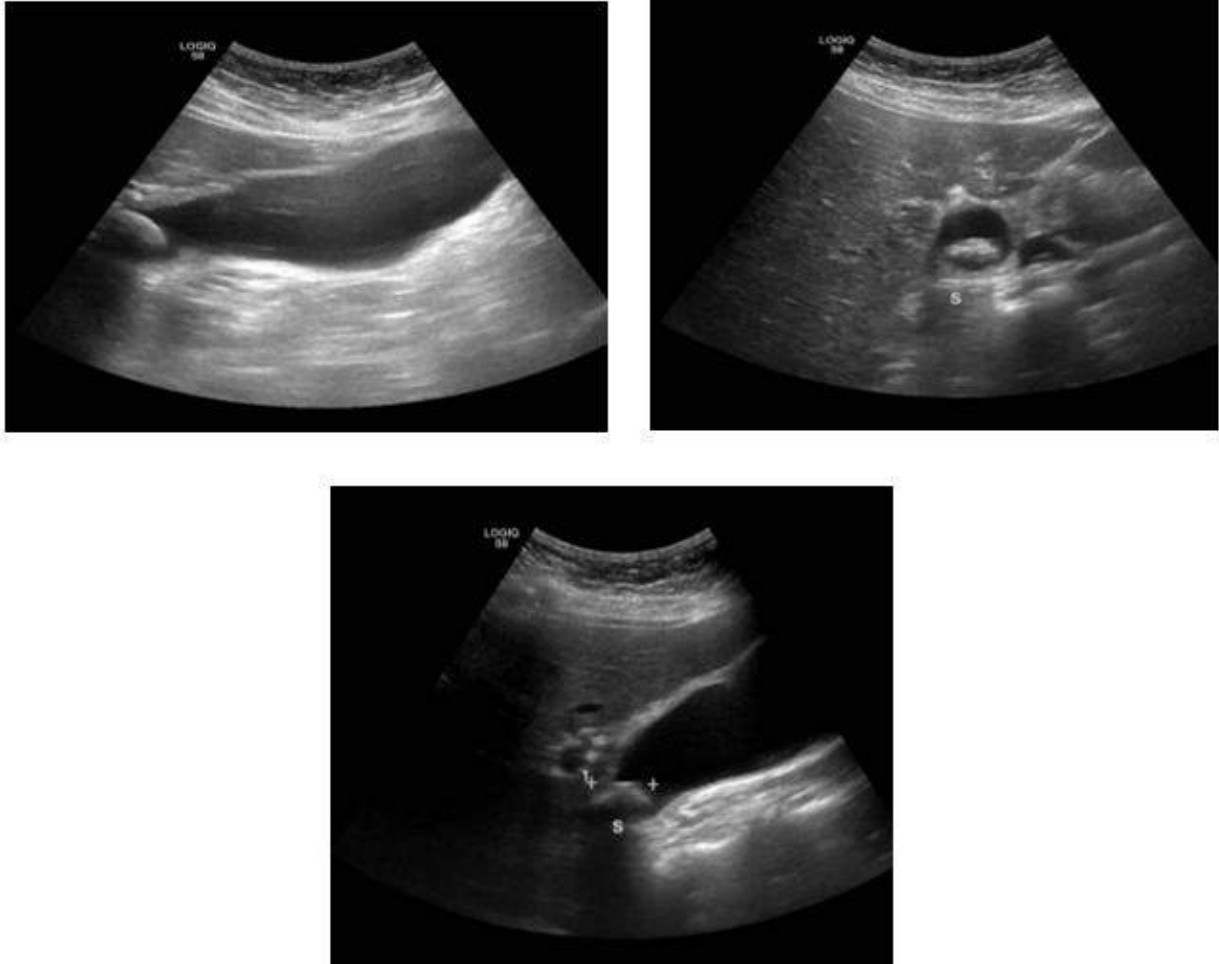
Abdominal ultrasound showed a hugely distended gall bladder.
